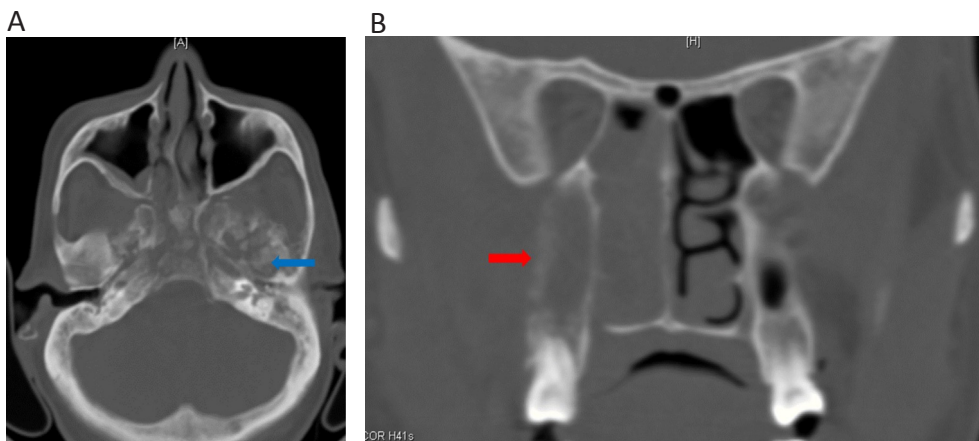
Multiple patients with bony involvement in chronic mucormycosis A - CT shows mixed areas of sclerosis and irregular lysis involving the anterior and middle skull base (blue arrow). B - Coronal CT shows rarefaction and thickening of the maxillary sinus with adjacent soft tissue density (red arrow).
